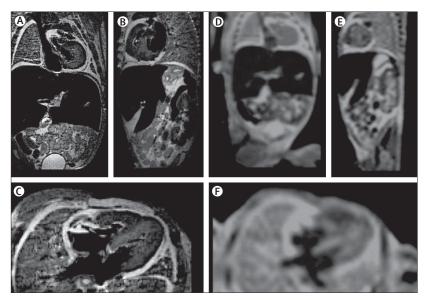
Fetus with skeletal dysplasia terminated at 22 weeks' gestation (A) Coronal, (B) sagital, and (C) axial images obtained with three-dimensional T_2 -weighted MRI at 9-4 T. (D) Coronal, (E) sagital, and (F) axial images obtained with three-dimensional T_2 -weighted MRI at 1-5 T. Images at 9-4 T showed healthy cartilage and internal organs.
